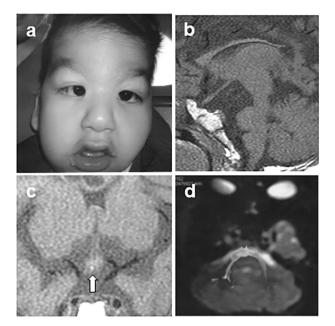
Clinical findings in the patient. a A front view of the patient at one year of age showing distinct facial features with strabismus, a broad forehead, micrognathia, a broad philtrum, and arched eyebrows. T1-weighted sagittal (b) and coronal (c) views of the brain magnetic resonance imaging show anterior pituitary hypoplasia, ectopic posterior pituitary (white arrow), thinning of the corpus callosum, and the pontine and the midbrain hypoplasia. d Diffusion tensor imaging and fiber tractography showing the presence of transverse pontine fibers. The authors have obtained informed consent from his parents to publication of these images
